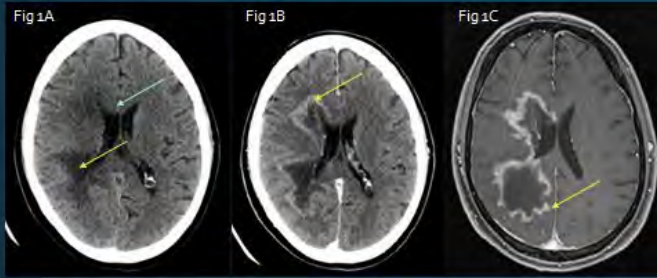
(A) Unenhanced CT of the brain show hypoattenuation of the right cerebral white matter, primarily concentrated within the frontotemporoparietal lobes. There is also evidence of mass effect, presumably from edema as suggested by effacement of the right frontal horn. (B, C) Contrast enhanced CT and MRI, he lesion demonstrated peripheral enhancement in the involved regions.
